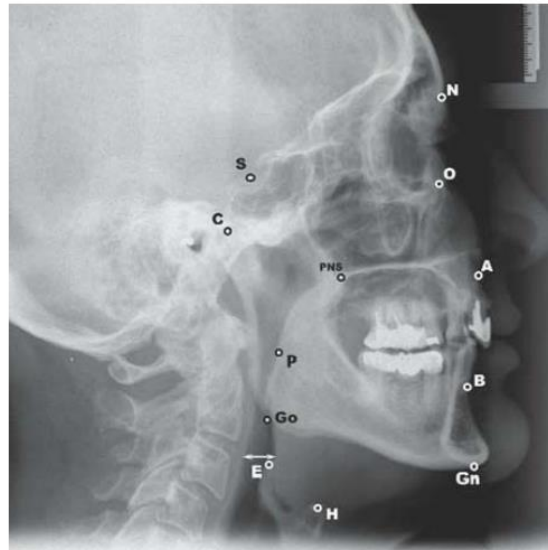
Lateral x-ray cephalogram. The cephalometric landmarks used in this study. *S* (sella), midpoint of sella; *N* (nasion), anterior point at the frontonasal suture; *ANS* (anterior nasal spine), most anterior point of the anterior nasal spine; *PNS* (posterior nasal spine), most posterior point of hard palate; *A* (subspinal point), deepest anterior point in concavity of the maxilla; *B* (supramental point), deepest anterior point in concavity of the mandible; *Gn* (gnathion), most inferior point of the mandibular symphysis; *H* (hyoid), most anterosuperior point of hyoid bone; *E* (epiglottis), base of epiglottis; *Go* (gonion), most posterior and inferior point of the angle of the mandible; *P* (soft palate), most inferior and posterior point of the soft palate; *MP* (mandibular plane), mandibular plane joining gonion with gnathion; *SNA* (deg), angle between nasion–sella line (NSL) and the line from *A* to *N* (measures projection, anterior or posterior of maxilla); *SNB* (deg), angle between NSL and the line from *B* and *N* (measures position of mandible); *ANB* (deg), angle between the line from *A* to *N* and the line from *B* to *N* (measures position of maxilla with mandible); *PNS–ANS*, linear distance between *PNS* and *ANS*; *ANS–H*, linear distance between *ANS* and *H*; *ANS–E*, linear distance between *ANS* and *E*; *PNS–P*, linear distance between *PNS* and *P* (measures length of velum of palate); *MP–H*, linear distance between the mandibular plane and *H*.
